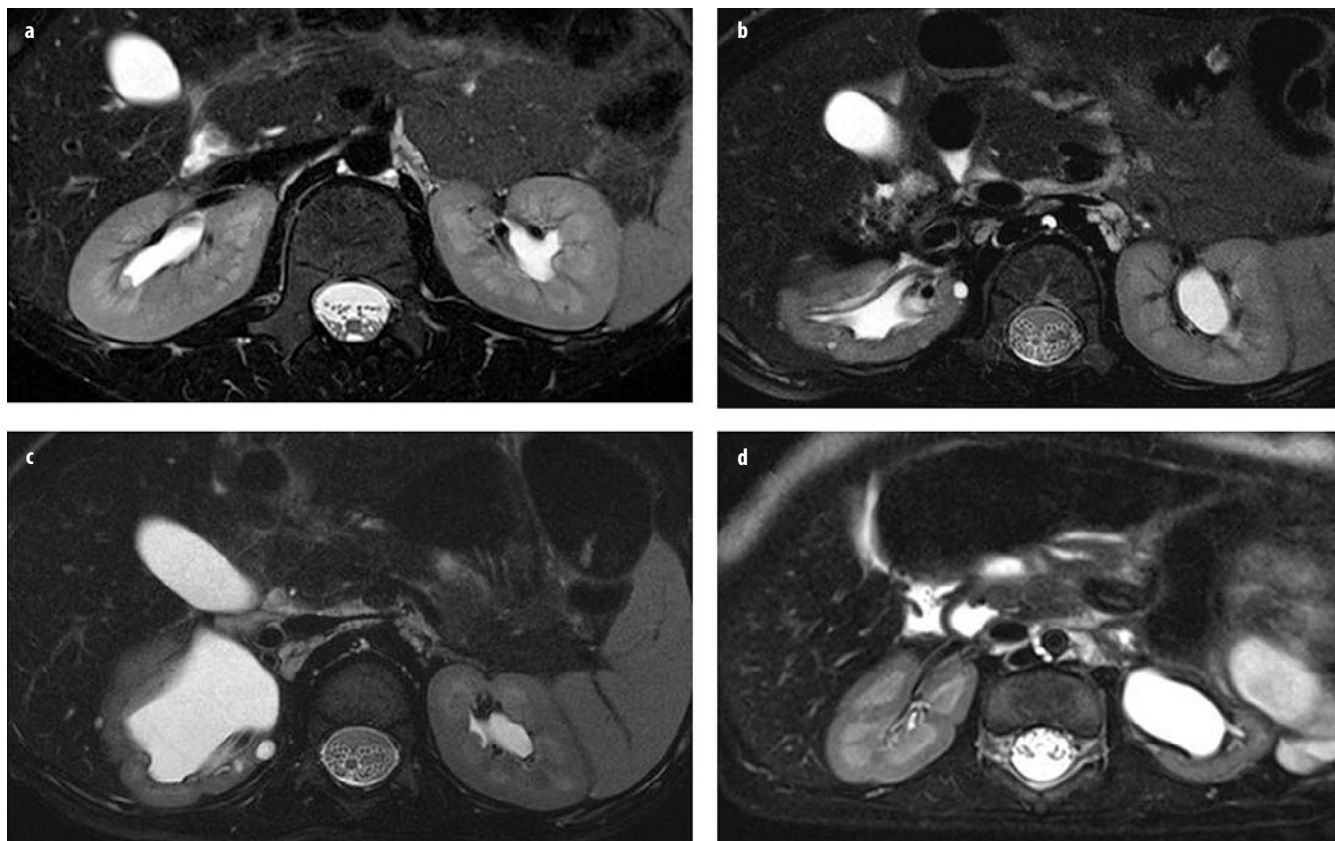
a-d. High-resolution T2-weighted magnetic resonance urograms (MRU) of the kidney. The image a shows a patient with normal renal anatomy; the other three images are examples of patients with renal dysplasia. The high-resolution T2-weighted images can be used to assess renal parenchyma quality. Excellent corticomedullary differentiation allows assessment of both the renal cortex and medulla, as well as detection of cysts, scarring, edema, and architectural disorganization
